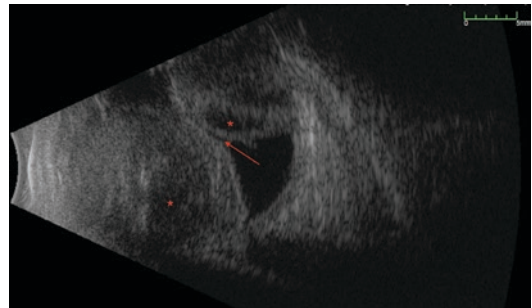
Ophthalmic brightness amplitude scan (B-scan) ultrasound of a hemorrhagic choroidal. B-scan demonstrating kissing (arrow) hemorrhagic choroidals, which occurred during phacoemulsification cataract surgery. At day seven, there is evidence of clot liquefaction (asterisks) which was critical when planning the timing of surgical choroidal drainage
